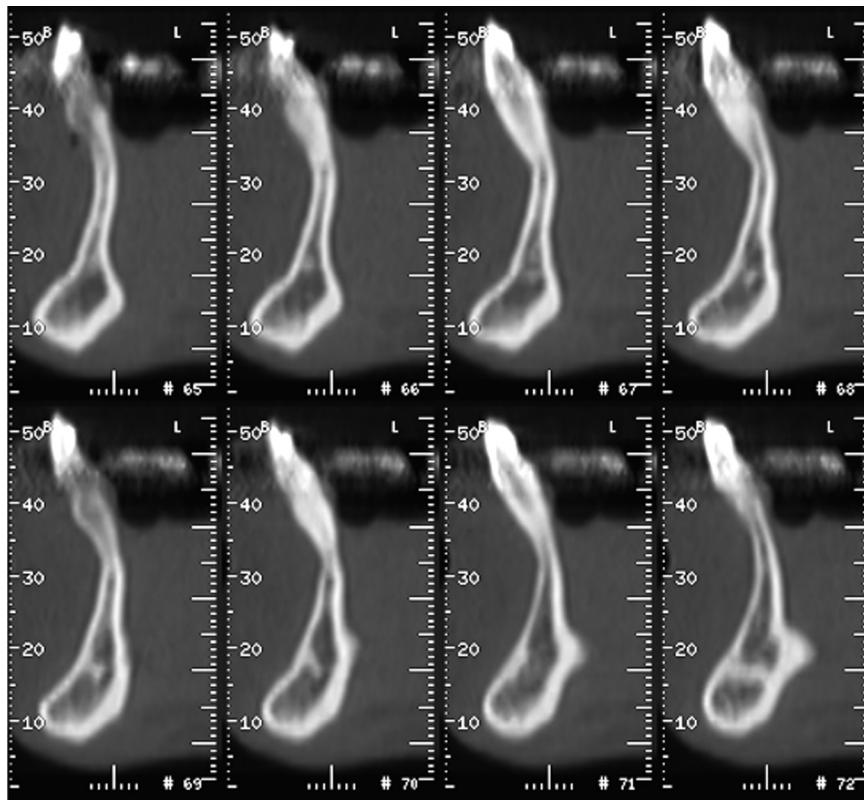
CT image reformatted in the sagittal oblique plane: the extreme thinness makes the symphysis mostly unsuitable for bone removal.
